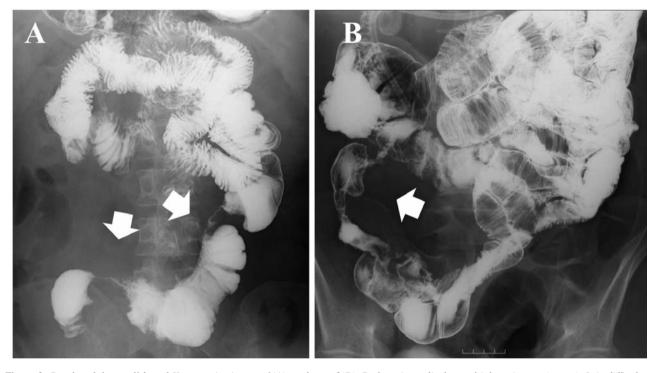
Results of the small bowel X-ray series in case 1(A), and case 2(B). Both patients display multiple strictures (arrow). It is difficult to distinguish Crohn's disease from the cancer.
